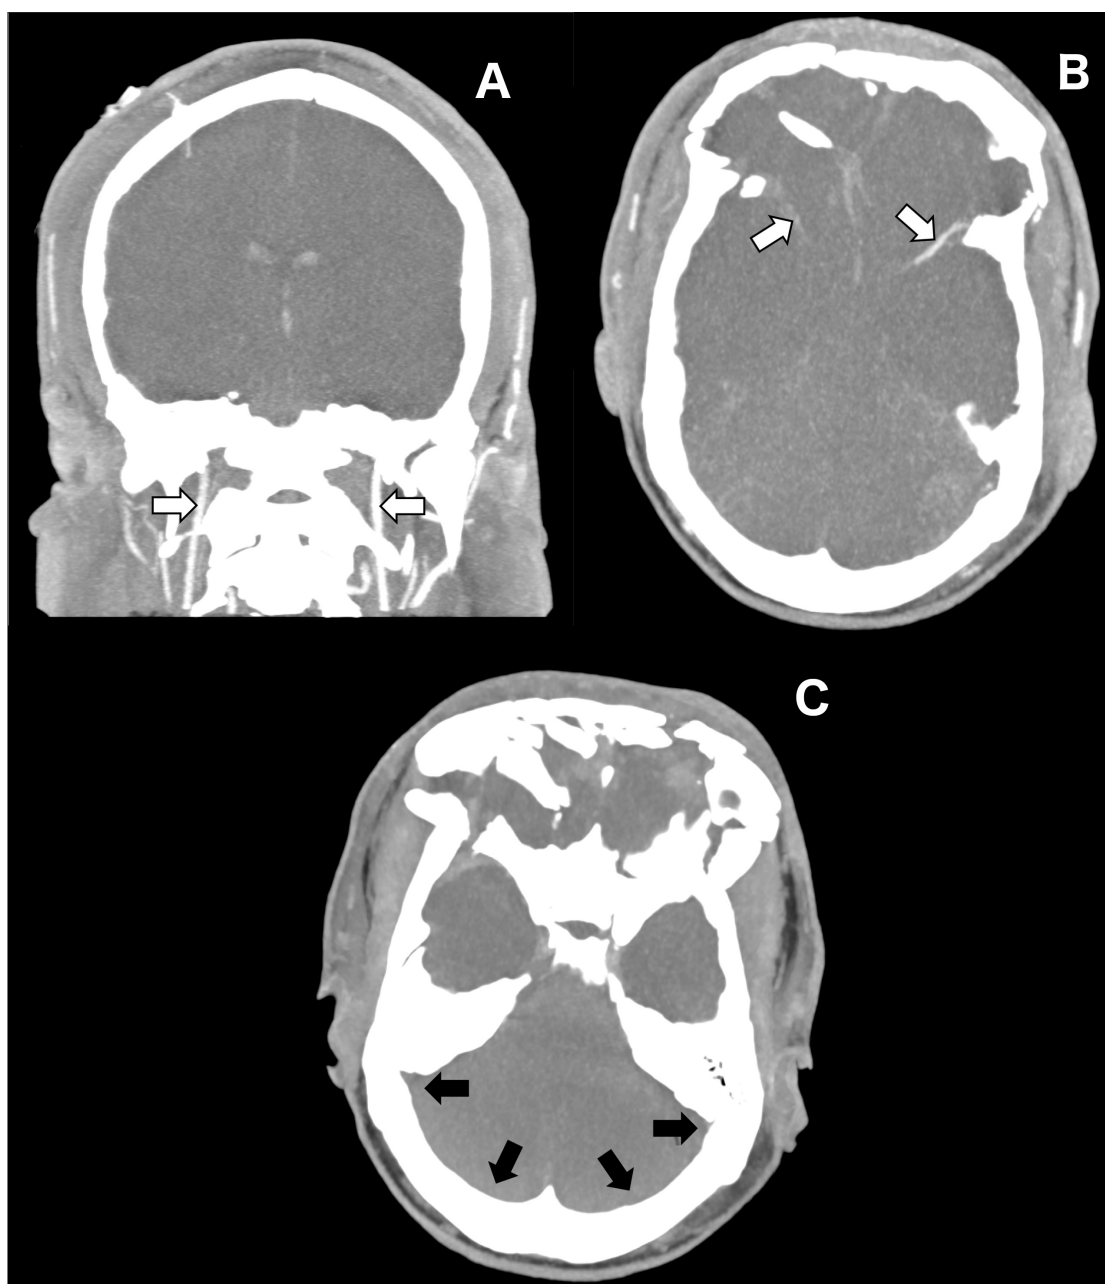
CT- angiogram (A, B) of patient with brainstem death after severe traumatic brain injury in whom extensive facial fractures prevented a full set of tests being carried out. Internal carotid arteries are opacified with contrast (A, arrows) but intracranial intravascular contrast is largely absent. Some opacification of the middle cerebral arteries (B, arrows) may nevertheless be seen due to pulsatile mixing of blood and this could be mistaken for blood flow demonstrating the need for caution in the interpretation of ancillary tests. However a CT venogram (C) does not reveal contrast in the transverse or sigmoid sinuses (at black arrows) demonstrating complete absence of venous drainage.
